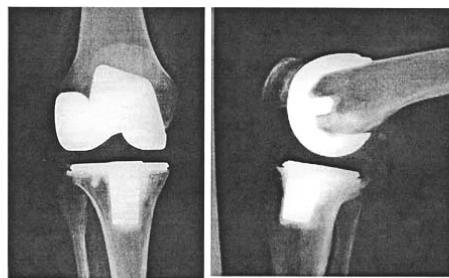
Anteroposterior and lateral radiographs of knee in Fig. 1 after revision to a standard AGC Total Knee Replacement.
